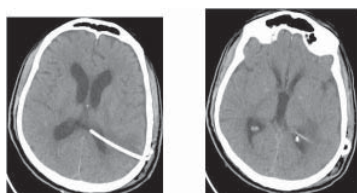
Showing latest patient's CT brain, showing placement of the VP shunt and resolving IVH
